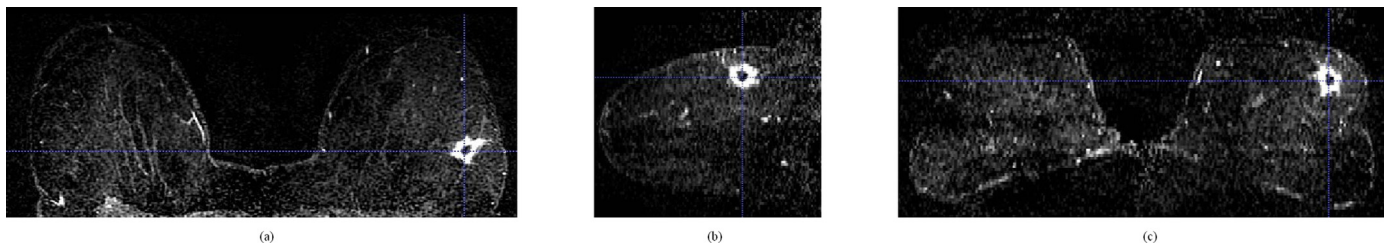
Sample T2-weighted MRI displaying Stage I from the TCGA-BRCA data set, (a) axial view, (b) sagittal view, and (c) coronal view.
